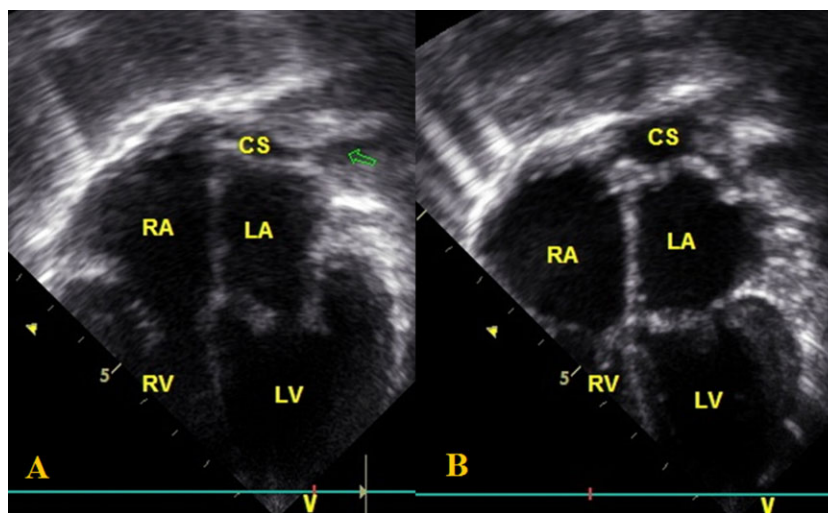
Apical four-chamber views after surgery. Coronary sinus (CS) is created above the roof of the left atrium (LA) with adequate flow to the right atrium (RA). RV, right ventricle; LV, left ventricle; arrow, persistent left superior vena cava.
